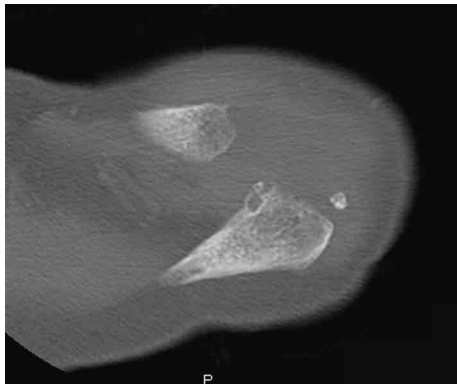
Computed tomography scan of an elderly patient with *os acromiale* of the left shoulder after excision. Post-operative CT scan shows that *os acromiale* was completely excised.
